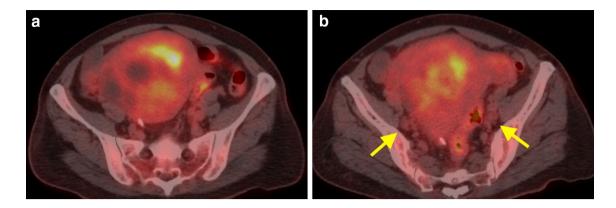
a and b FDG PET/CT revealed minimal FDG uptake in the uterus and lymph node lesions (arrow)
